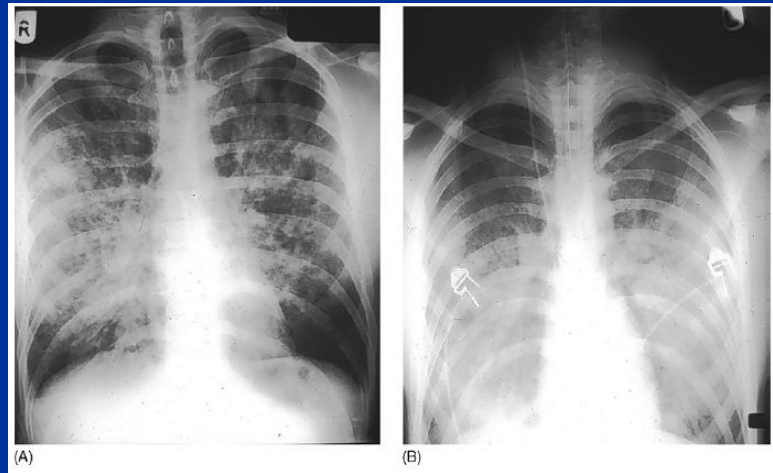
Transfusion-related acute lung injury. A, This patient had a normal chest radiograph prior to transfusion. B, Pulmonary edema in a chest radiograph taken 2 hours after a transfusion. C, Pulmonary edema was markedly improved 48 hours later.
